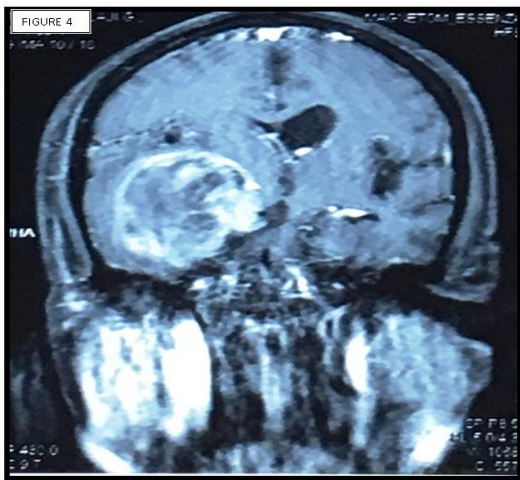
shows MRI showing tumor in the right ventricle.
